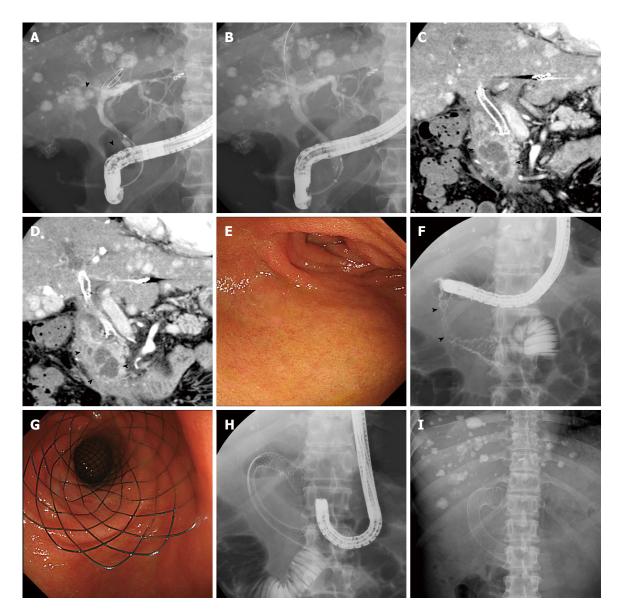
Case of hepatocellular carcinoma. A: Cholangiogram showing a biliary stricture caused by primary tumor and lymph node metastasis in the right hepatic duct and middle bile duct (arrow heads); B: A self-expandable metal stent was inserted endoscopically; C, D: Coronal sections of contrast-enhanced computed tomography images show duodenal invasion of lymph node metastasis (arrow heads); E: Endoscopic view showing the oral side of the stricture at the superior duodenal angle; F: Injection of contrast material demonstrates a stricture in the second duodenal segment (arrow heads); G, H: A nitinol metal stent was placed in the shape of the character "C" from the stomach pylorus to the third duodenal segment (G: Endoscopic view; H: X-ray); I: X-ray image taken 1 wk later shows sufficient expansion and stability of the duodenal stent.
